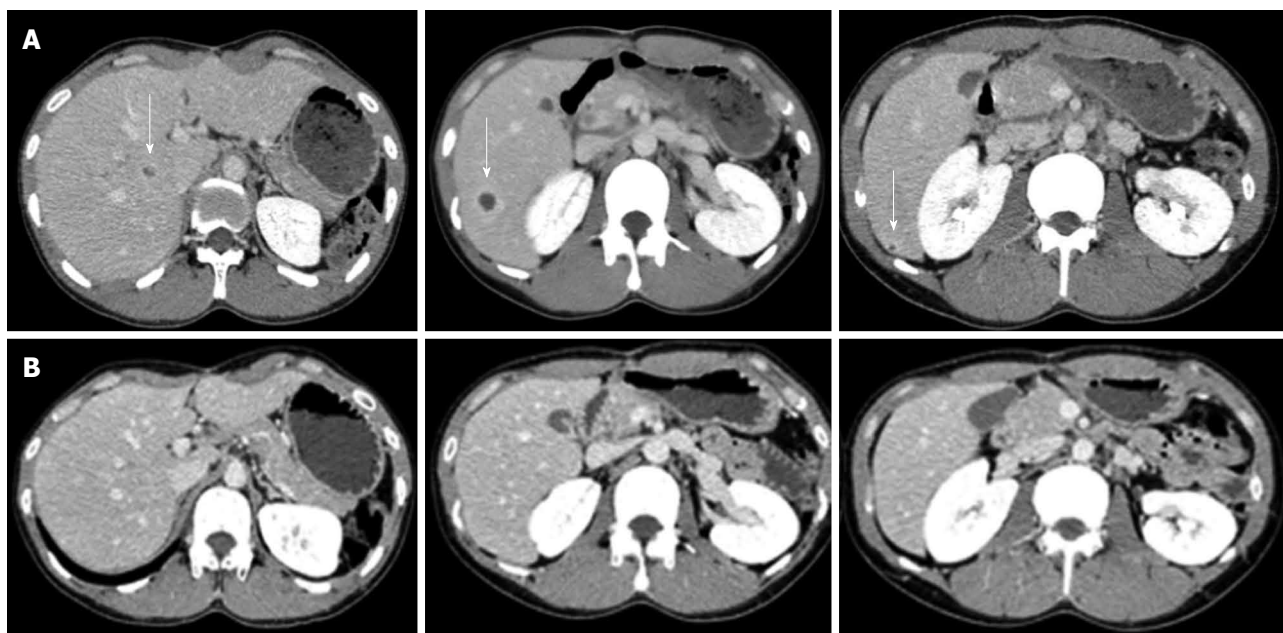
Contrast-enhanced abdominal computed tomography scan showing multiple liver abscesses (arrow) before (A) and 4 wk after corticosteroid therapy (B). Multiple areas of low-attenuation with ring enhancement were seen in the liver as indicated by the arrows (A). However, the areas vanished after treatment (B).
